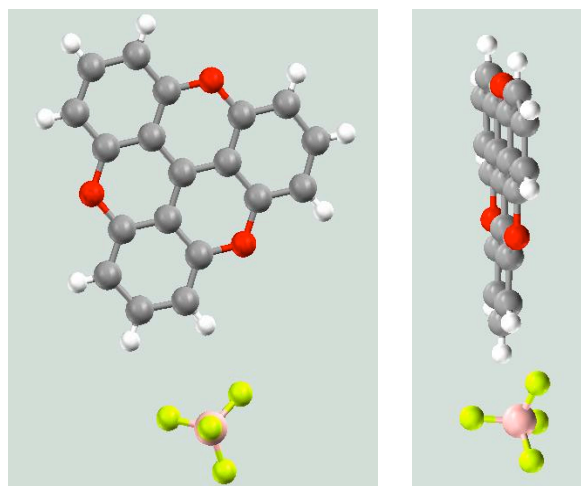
X-Ray of Martin's salt ($\text{TOTA}^+ \text{BF}_4^-$), showing the flat structure
